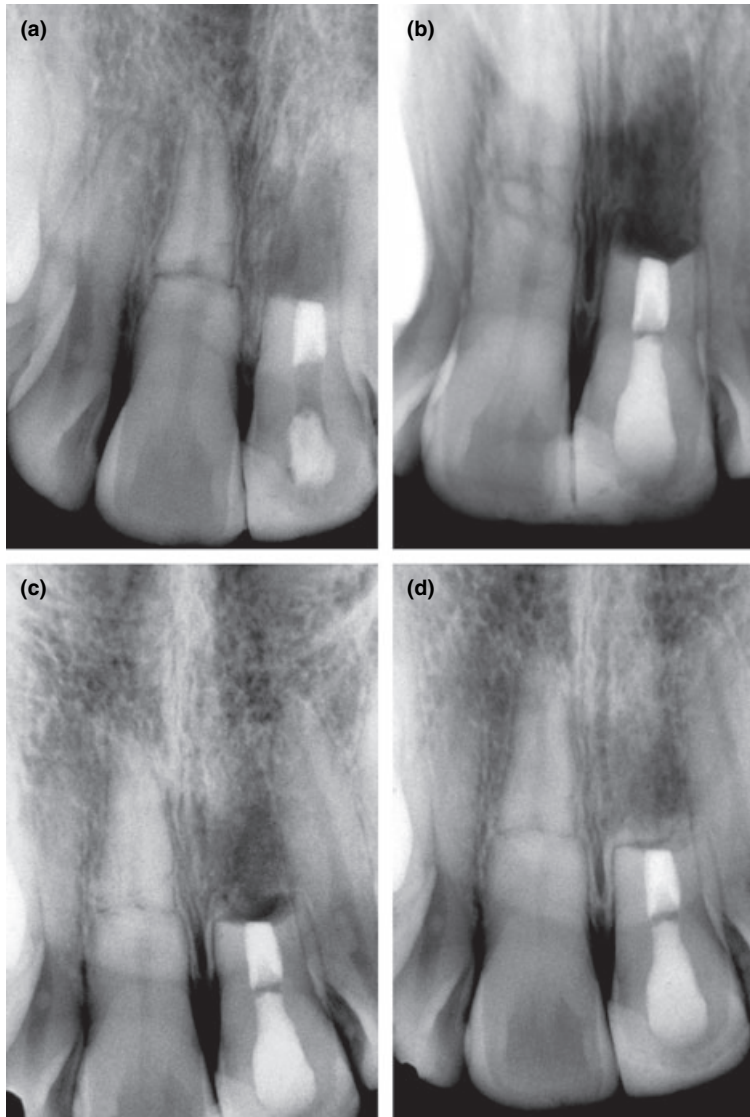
Radiographs taken at different periods after root canal and surgical treatment of tooth 21: (a) 1 month; (b) 3 months; (c) 6 months, and (d) 1 year.
